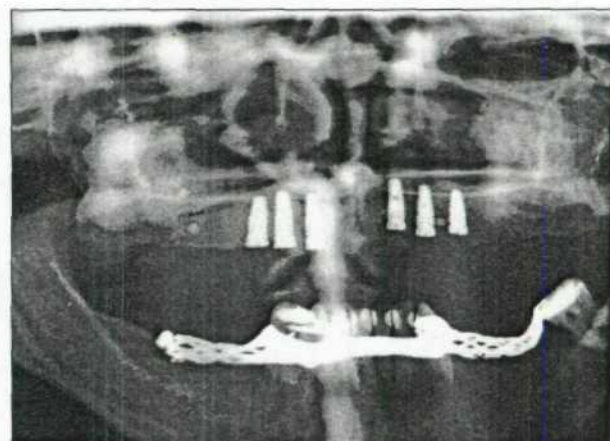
Panoramic radiograph following bilateral sinus graft surgery, demonstrating the fill of the sinus cavities with xenograft particles on one side and xenograft with autogenous bone on the other side.
